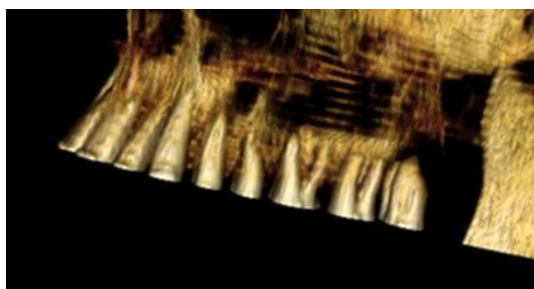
(a) upper left teeth roots of the antemortem mid-face CT with 100% opacity over upper left teeth roots of PMCT.
